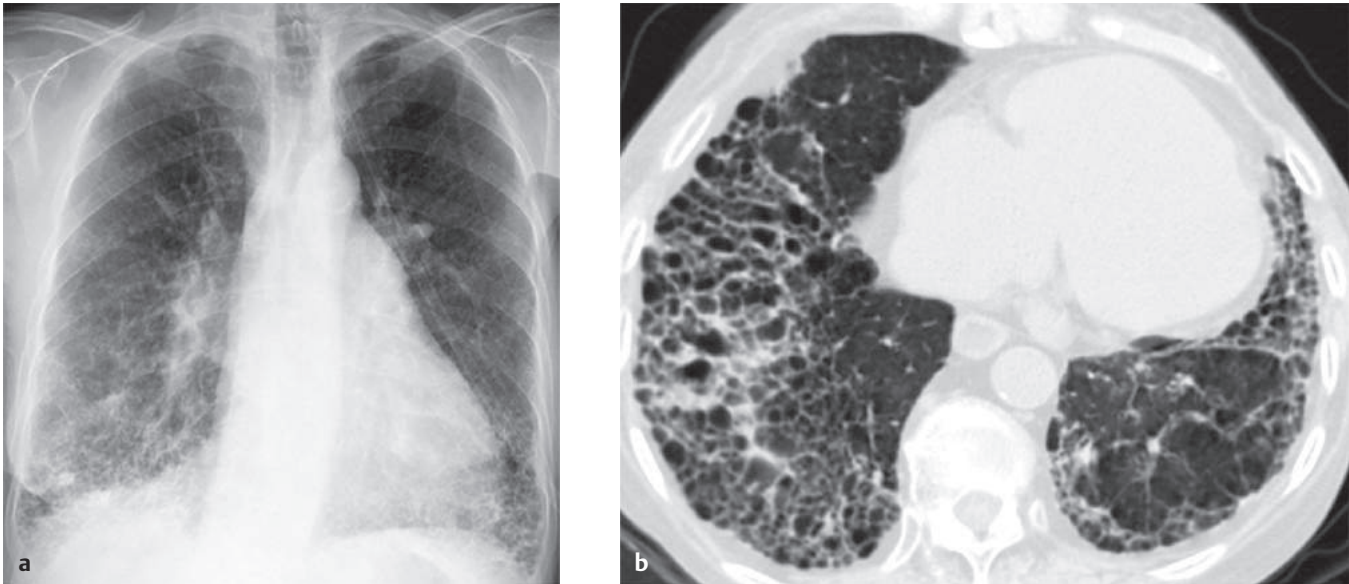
(a) Frontal chest radiograph demonstrates coarsened interstitial lung markings predominantly at the lung bases. (b) Axial CT image shows traction bronchiectasis and fibrotic changes predominantly in the lower lobes and a dilated, patulous, fluid-filled esophagus.
